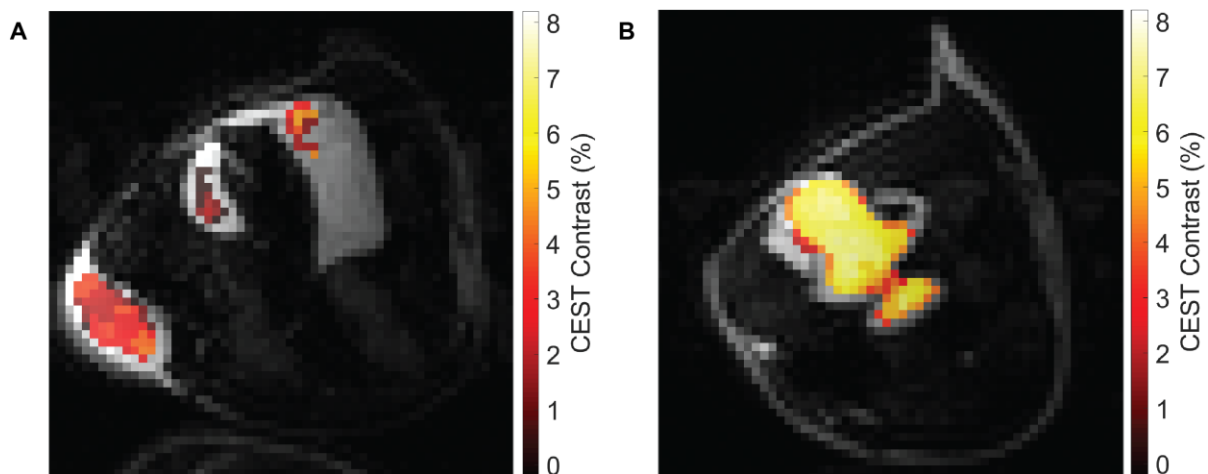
Representative CEST Contrast Maps of Empty and AAV Hydrogel In Vivo at 7 T. (A,B) CEST contrast maps overlaid on T2-weighted images for empty hydrogel and AAV-laden hydrogel, respectively.
